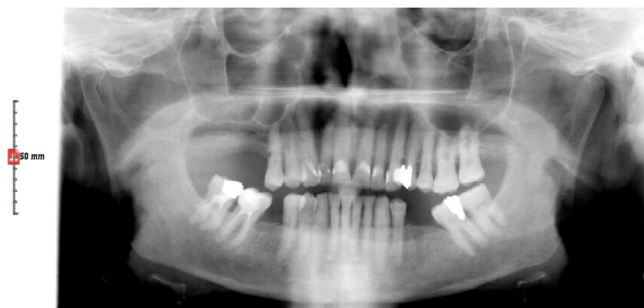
First dental panoramic x-ray images (December 2008).
